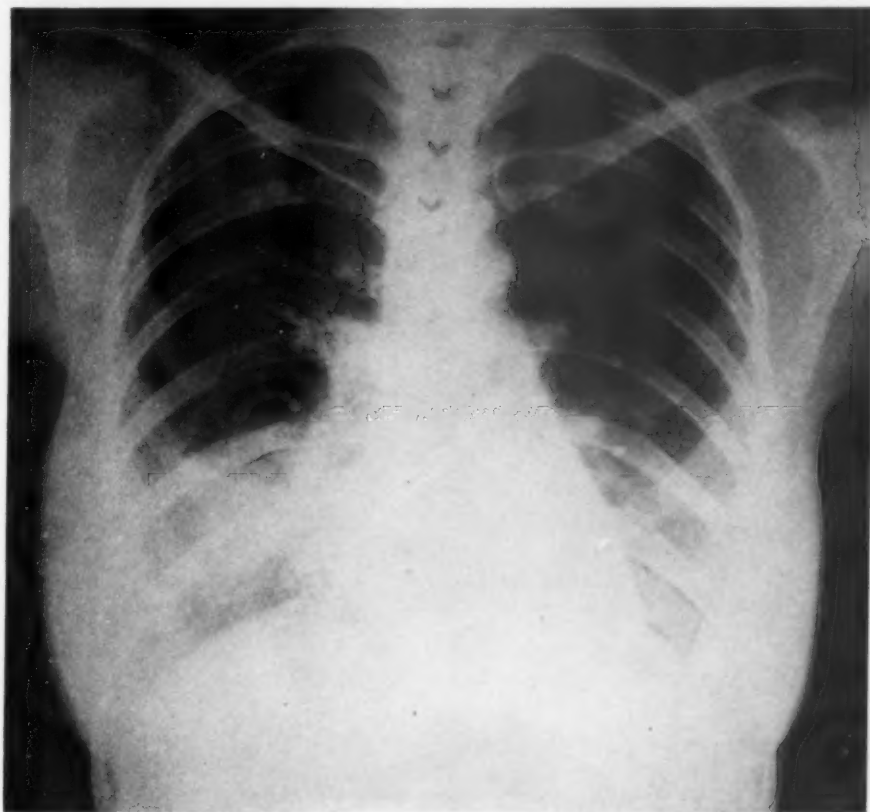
(Case 2.) Roentgenogram taken October 28, 1937. Infiltration in the right infraclavicular region with bronchogenic spread to the right base.
